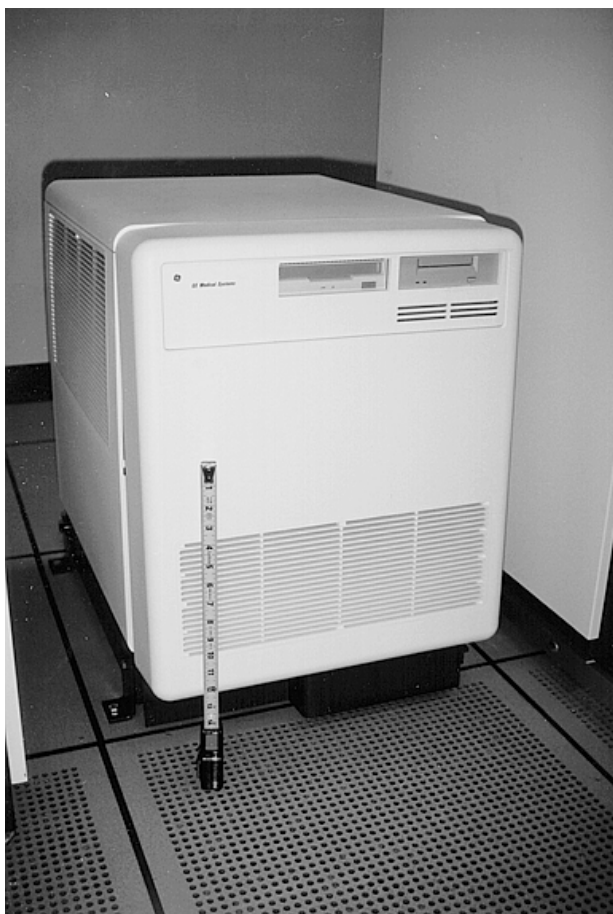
Computer that records MRI results, anchored to a single computer floor tile.
